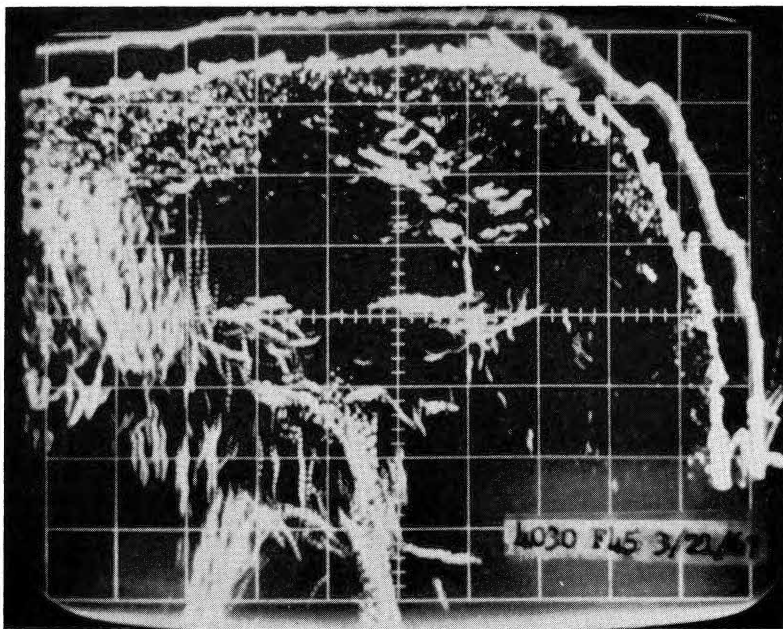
Shows the scattered echo pattern of the liver sonogram of a woman with metastatic carcinoma of the liver confirmed at autopsy.
